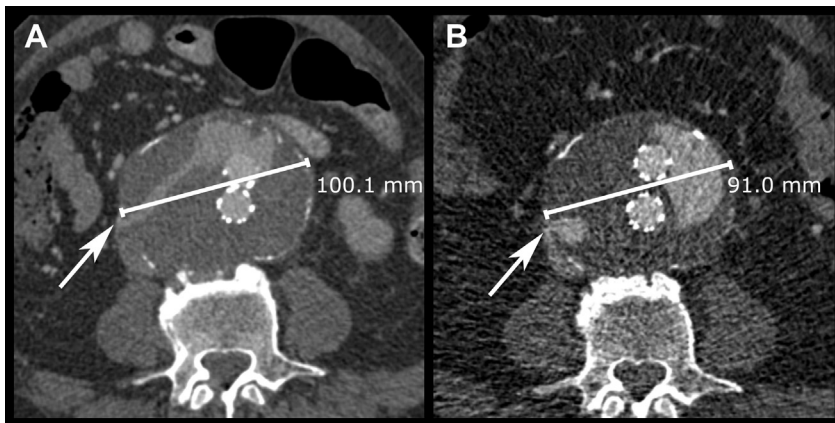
Postoperative computed tomography angiography (CTA) at (A) 6 weeks and at the (B) 1-year follow-up shows a 10-mm decrease in diameter. Notice the large type II endoleak associated with a persistent aortocaval fistula (white arrowheads).
